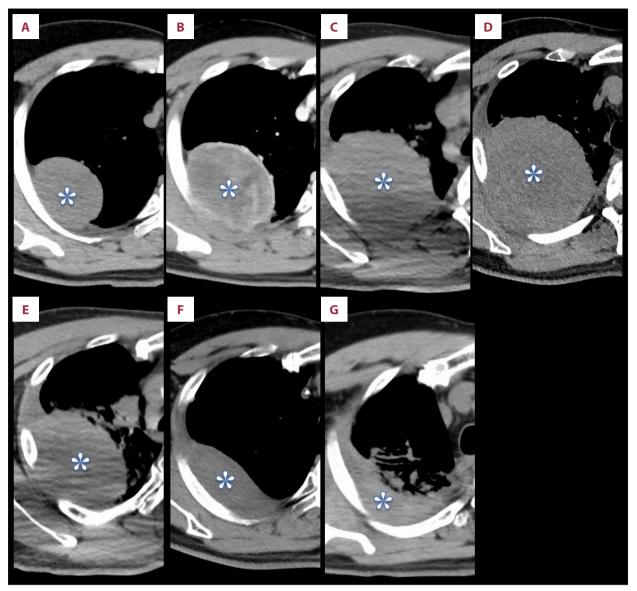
CT axial images before and during the treatment. A (Day -37), B (Day -18), C (Day -4), D (Day 11), E (Day 29), F (Day 51), G (Day 282). A, B, images before treatment; C-F, images during chemoradiotherapy; G: follow-up CT image taken during durvalumab maintenance. The asterisk indicates a primary tumor.
